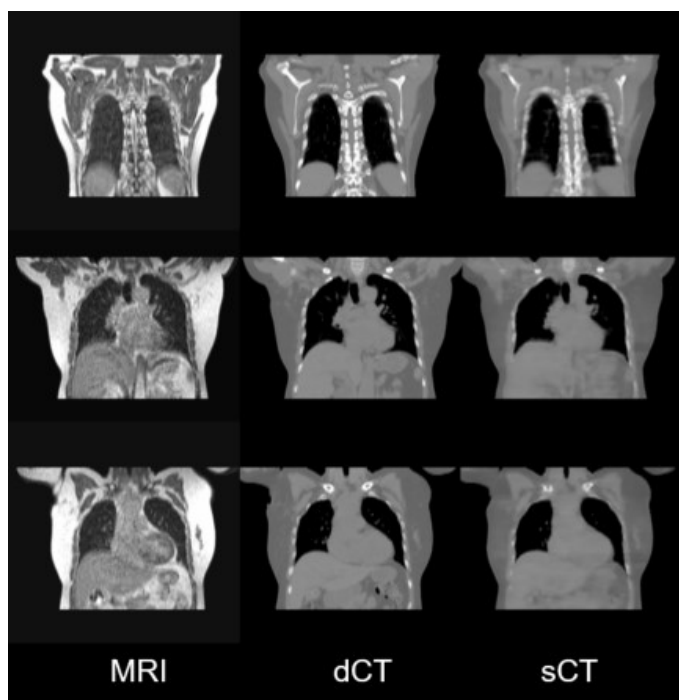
The representative coronal slice views of MRI, dCT and sCT for thorax
